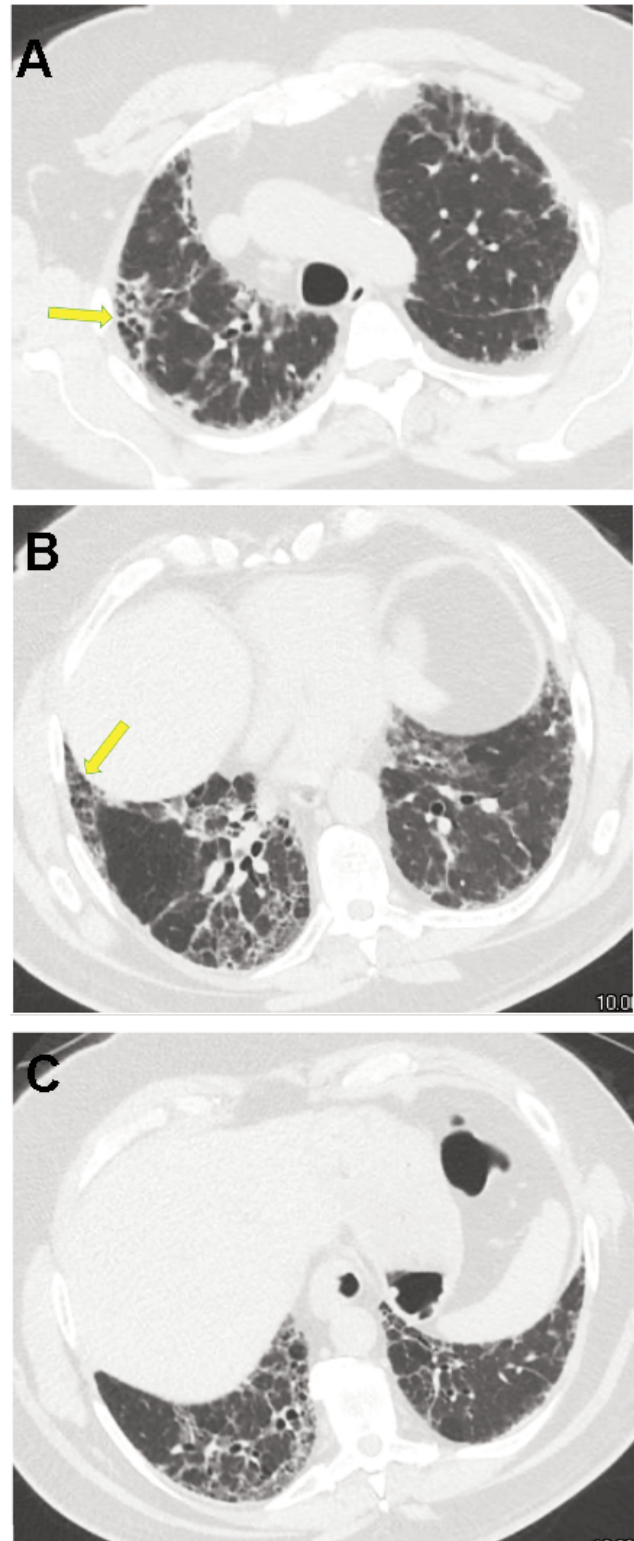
Axial HRCT scans at follow up from a patient with RA-ILD at the level of the aortic arch (A), right inferior pulmonary vein ostium (B), and just above the hemidiaphragms (C). The fibrosis has clearly progressed with worsening of the peripheral reticulation and traction bronchiectasis/bronchiolectasis. Honeycombing (arrows) is present. This is a UIP pattern of lung injury.
